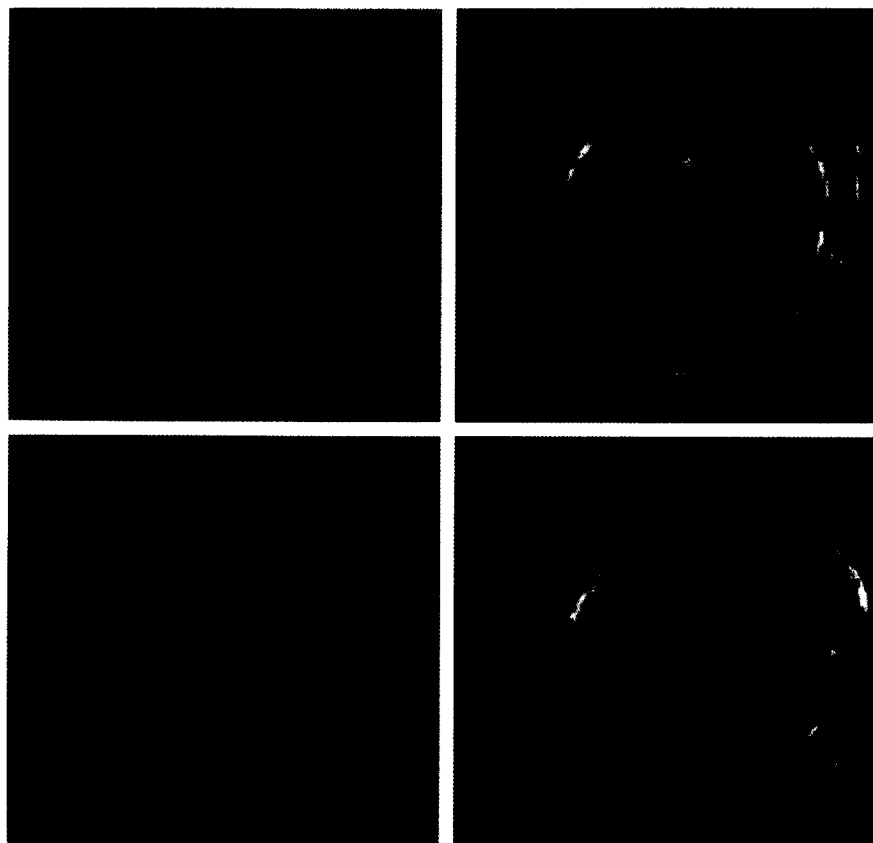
On the left are two control radiographies showing two different positions of the catheter. On the right are the two corresponding IVUS slices.
